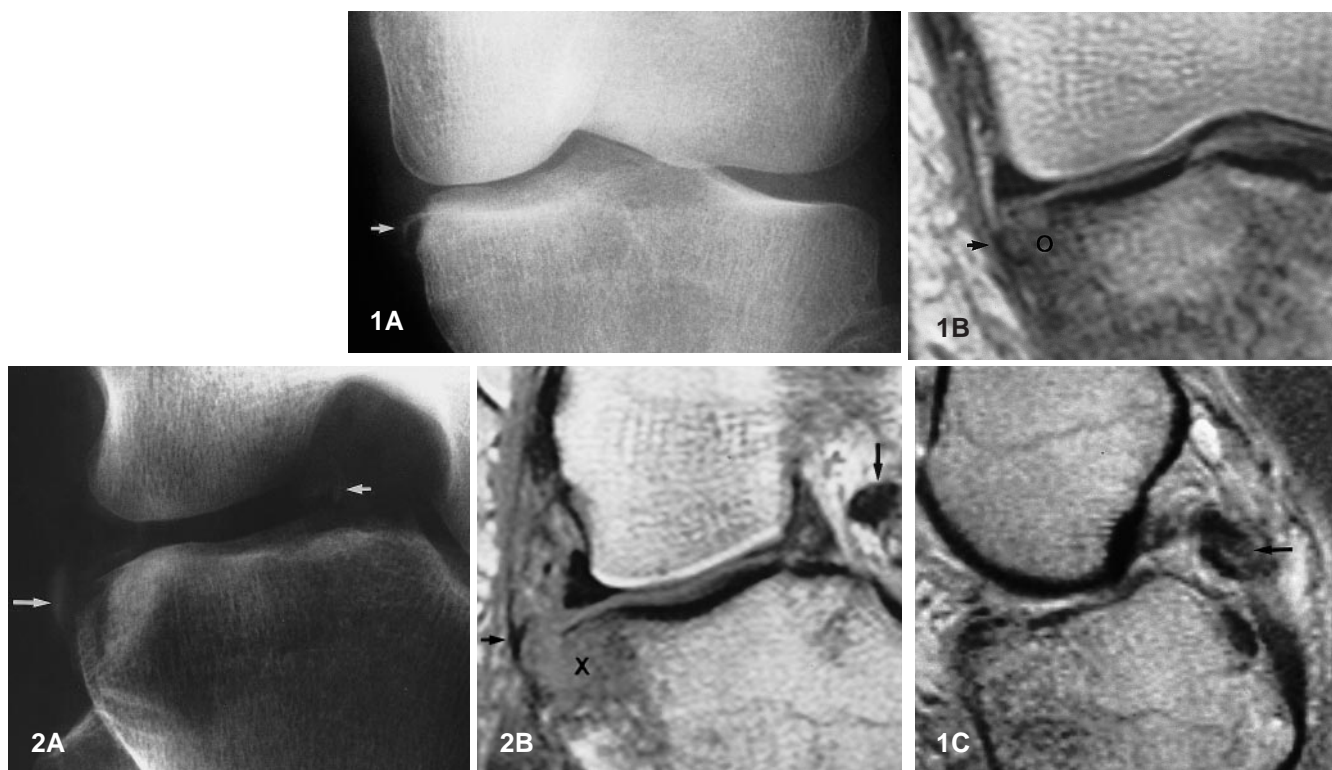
Medial Segond-type fracture and injury complex of the left knee. A Anteroposterior plain radiograph of the left knee demonstrates a small cortical avulsion fracture off the medial rim of the medial tibial plateau (*arrow*). Aside from this fracture and an effusion, the plain knee radiographs were normal. B Coronal T1-weighted MR image of the left knee demonstrates the avulsed cortical fragment off the medial tibial plateau (*arrow*) with a contusion and equivocal fracture of the contiguous trabecular bone (*O*). The medial meniscus is normal on this single view, but was torn on other images, as was the medial collateral ligament. C Sagittal paramidline T1-weighted MR image of the left knee demonstrates disruption of the posterior cruciate ligament (PCL) (*arrow*)
